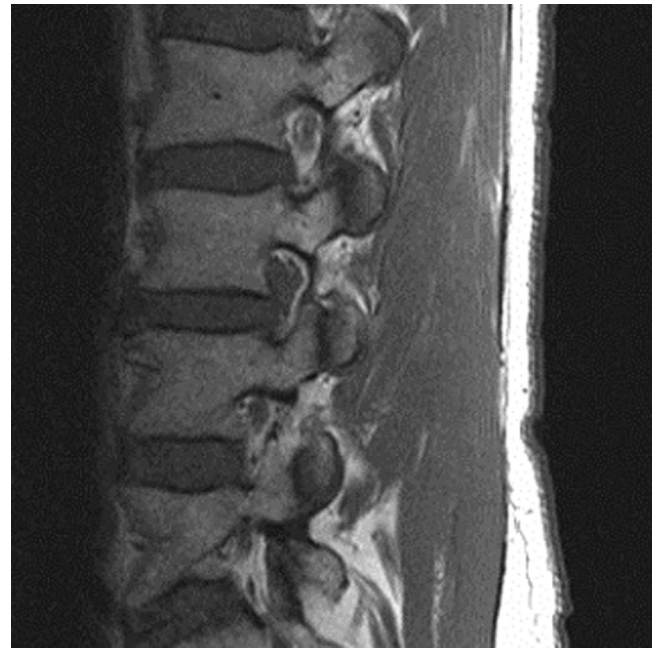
Lateral magnetic resonance image showing the right-sided upward intraforaminal disc herniation at the L3-L4 level with compression on the L3 nerve root.
